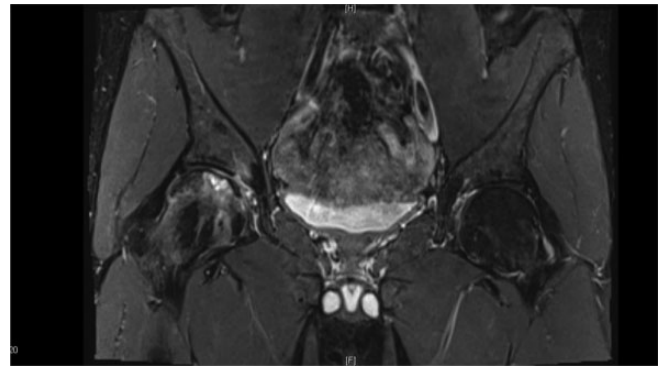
Magnetic resonance imaging 18 months after injury demonstrates an increase in size of the osteochondral lesion, subsequent cyst formation, and edema within the femoral head and subchondral zone.
